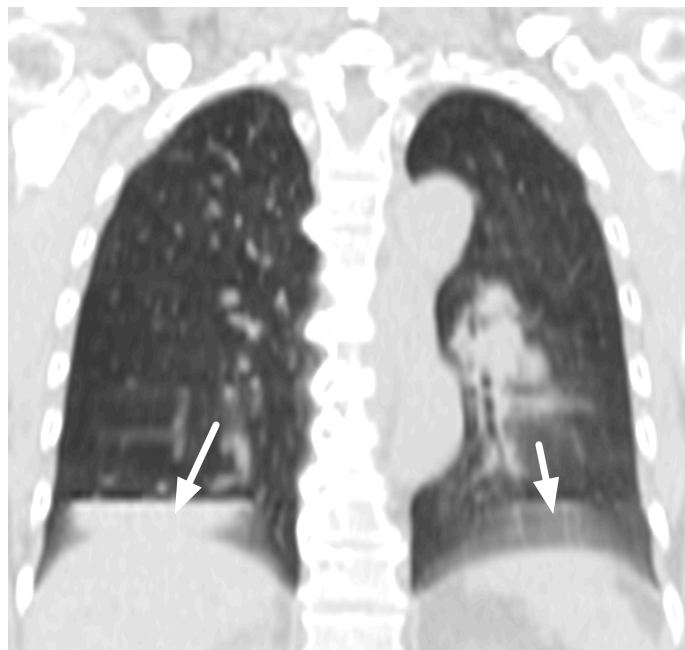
Severe motion artifact at the dome of the diaphragm (white arrow) due to irregular breathing during 4D-CT acquisition
